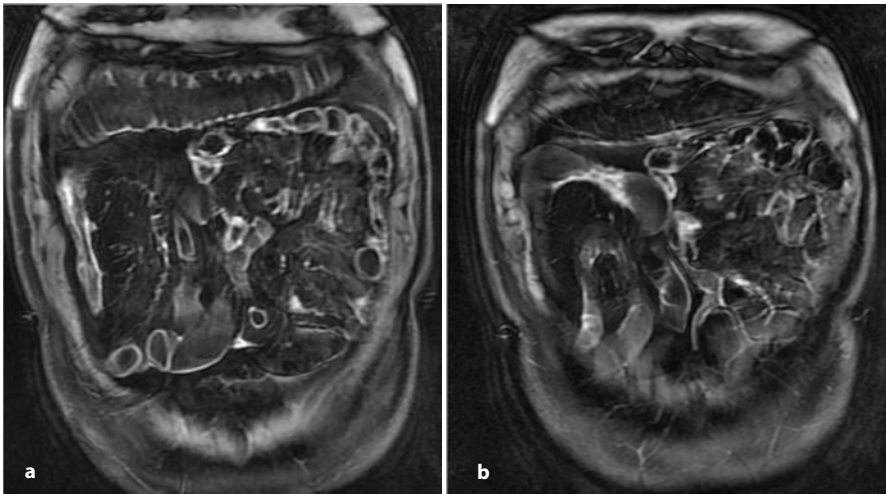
Coronal 3D spoiled gradient-echo (SPGR) T1-weighted sequence after i.v. administration of a paramagnetic contrast agent: longitudinal and transversal ulcerative lesion findings
